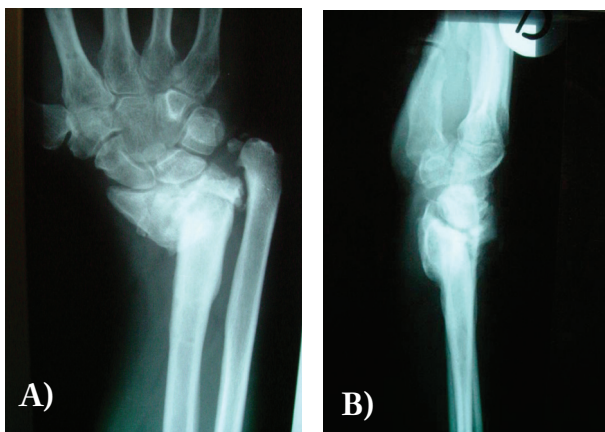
(Case 1). A) Preop AP view X-ray; B) Preop LL view X-ray
